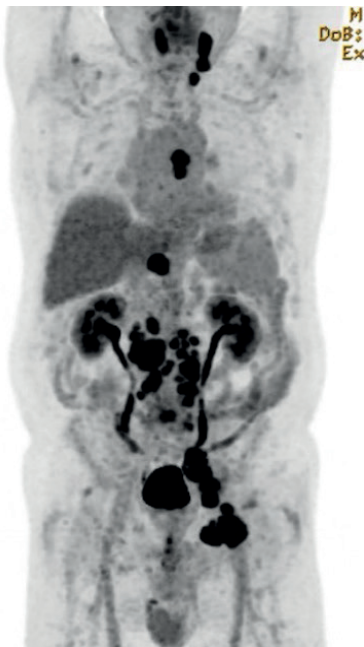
Staging positron-emission tomography-computed tomography showed fluorodeoxyglucose-avid lymphadenopathy along the cervical chain, above and below the diaphragm, and in the left groin, the largest measuring approximately 4.5 x 4.5 cm.
